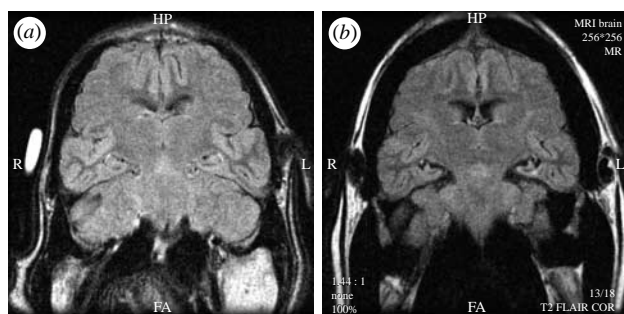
The magnitude of hippocampal atrophic changes was classified from normal to severe. T2-weighted images showing a sea lion with (a) bilaterally normal hippocampi and (b) a chronic neurological case with severe bilateral hippocampal atrophy, moderate bilateral thinning of the parahippocampus accompanied by bilateral temporal horn enlargement.
